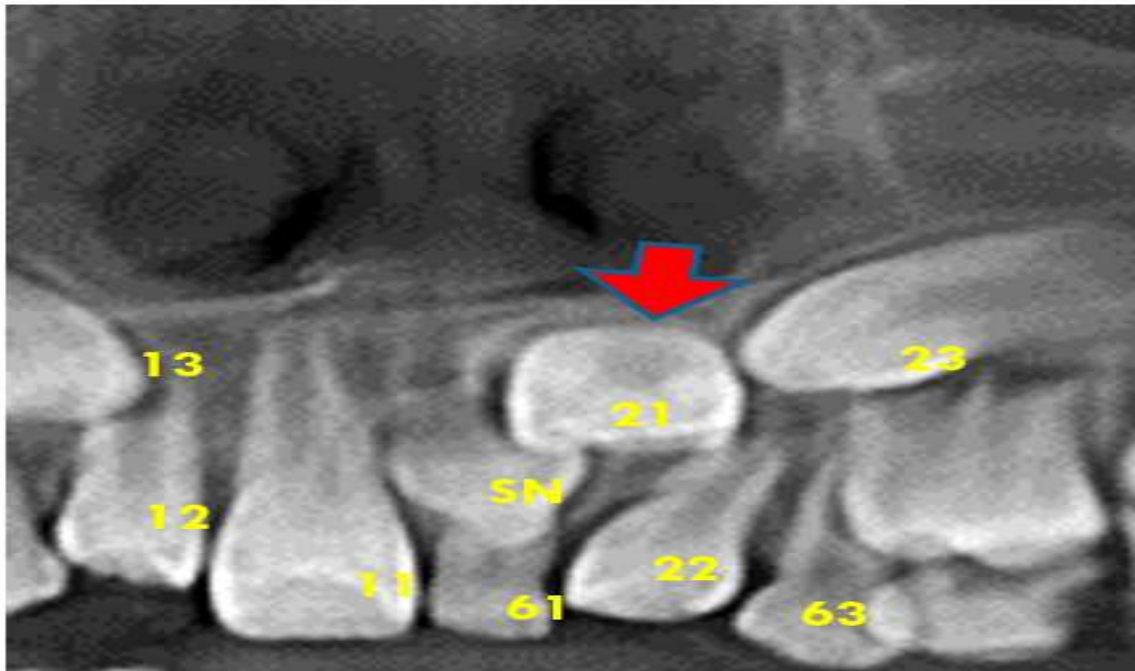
CBCT sagittal section showing a horizontally impacted permanent maxillary left central incisor (21) positioned labially, with a palatally placed developing mesiodens (arrow) and retained primary maxillary left central incisor (61)
